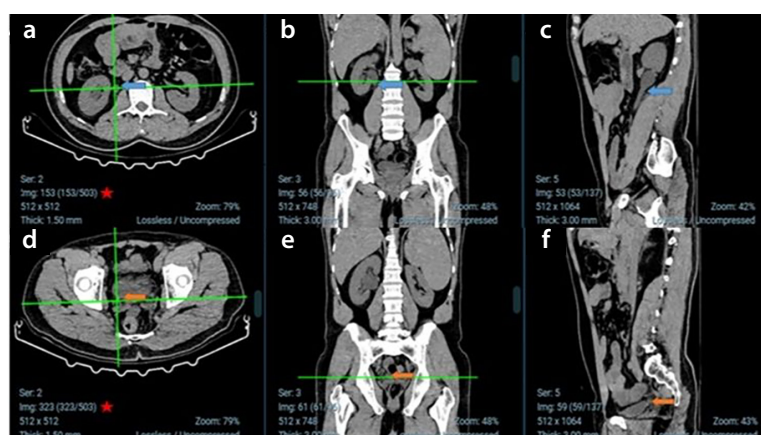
Measurement of ureteral length: The ureteropelvic junction (a, transverse; b, coronal; c, sagittal; blue arrow) and ureterovesical junction (d, transverse; e, coronal; f, sagittal; orange arrow) levels were identified on reformatted CT images. Ureteral length was determined by counting the number of transverse lines (red stars) between the two levels based on the section thickness parameter. CT, computed tomography.
